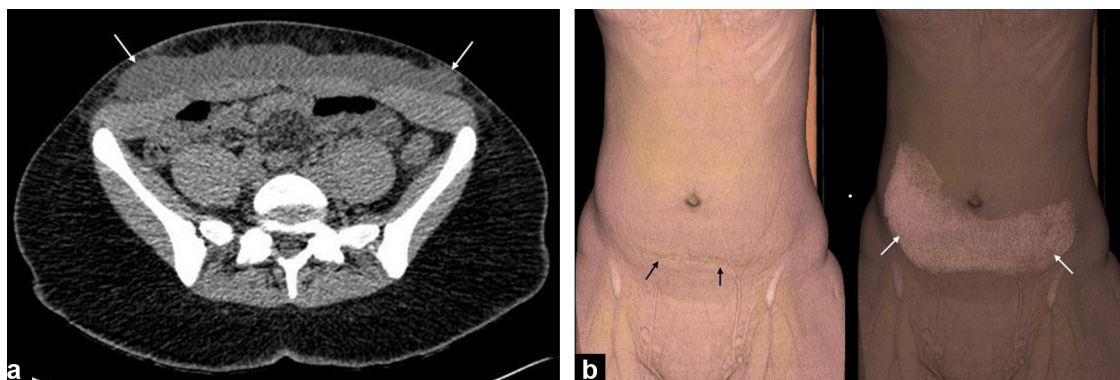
22 year-old woman with abdominal post-traumatic Morel-Lavallée seroma: first day of admission, abdominal CT, axial view (a) and volume rendering (b) showing a lentiform homogeneous fluid (20 UH) collection (white arrows) between subcutaneous fat and muscular rectus abdominis fascia.
